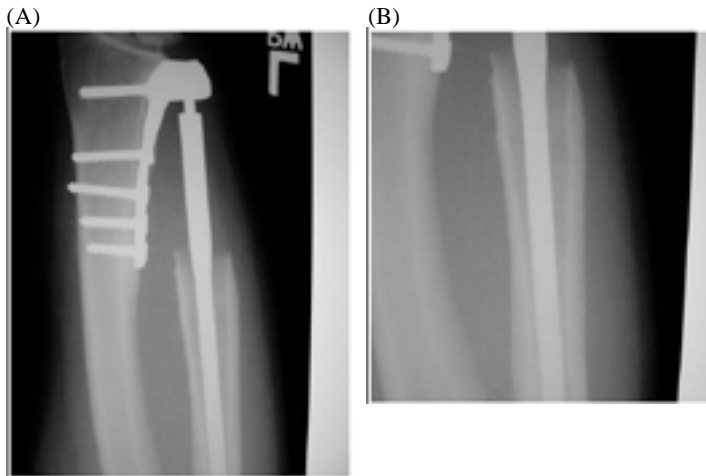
X-ray of the patient's left wrist with the Scheker prosthesis in place thirteen months post-operatively, showing signs of some loosening of the ulnar component.
